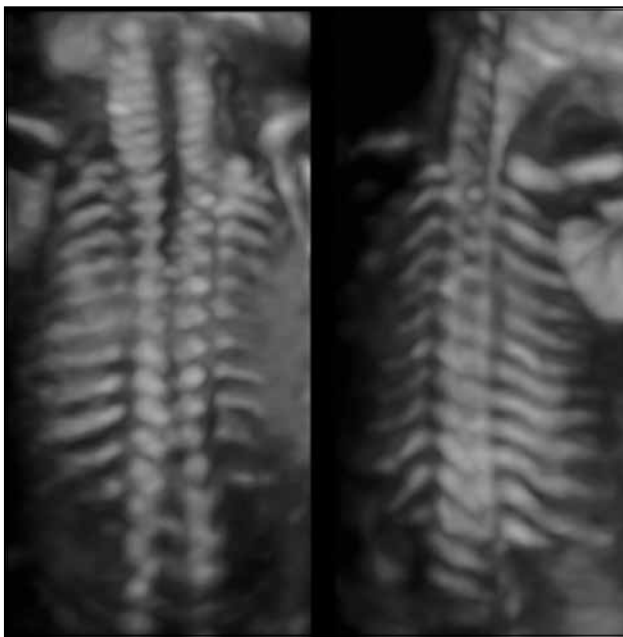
Volume contrast ultrasonographic images demonstrating normal number of ribs in a fetus
